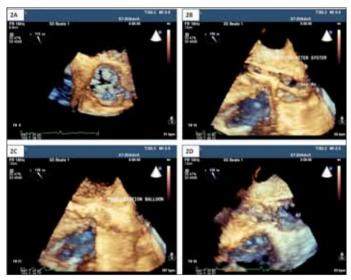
Procedural guidance of the real-time 3D echocardiographic imaging .2A. 3D Volume rendering "en face" view of the aortic valve from the aortic root. The valve appears heavily calcified, thickened with a very limited systolic opening. 2B. Real-time 3D imaging of the balloon inflation inside the aortic valve. 2C. Real-time 3D monitoring of Edwards Saphien valve-catheter system crossing the aortic valve and its positioning within the ventricle. After device release, the correct position of the valve checked again by real-time 3D TEE. 2D. Bioprosthetic aortic valve after TAVI by volume-rendered views in apical long axis view
